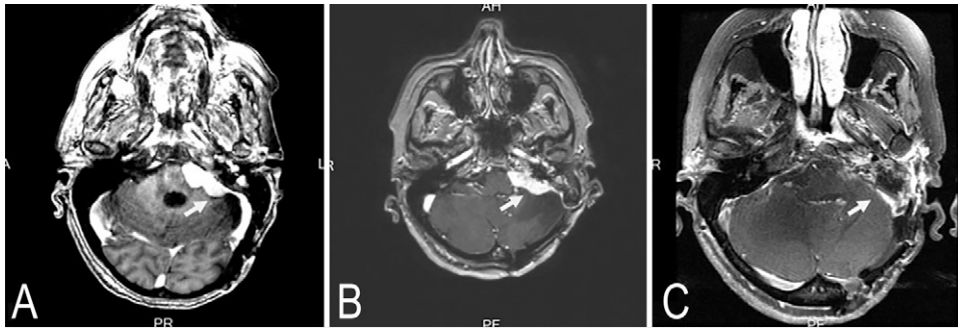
Axial view MRI T1-contrast images showing a heterogeneously enhancing mass extending from the left perimesencephalic/CPA cistern through the left hypoglossal and jugular foramen to the cervical region. Recurrence of the tumor (A), preoperative (B), postoperative (C) scan showing gross total removal of the tumor through left transotic craniectomy and cranioplasty.
